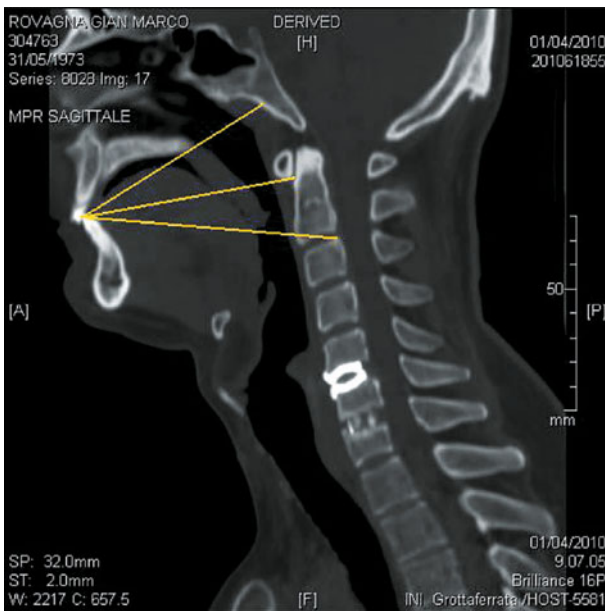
Computed tomographic scans demonstrating the surgical trajectory and angles for the the transoral approach (personal observation)
